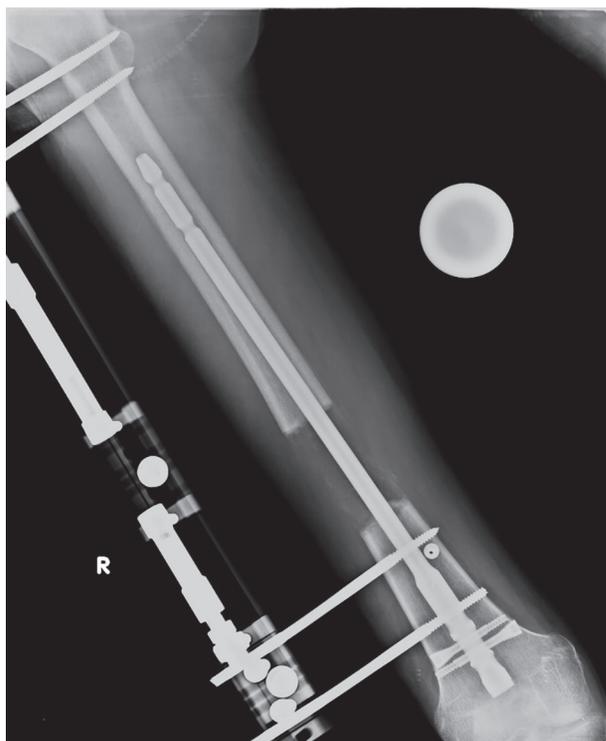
An x-ray of a patient during the lengthening period is shown. Lengthening over a retrograde intramedullary nail technique has been used (right femur). Note that a unilateral fixator is used for distraction of the femur
